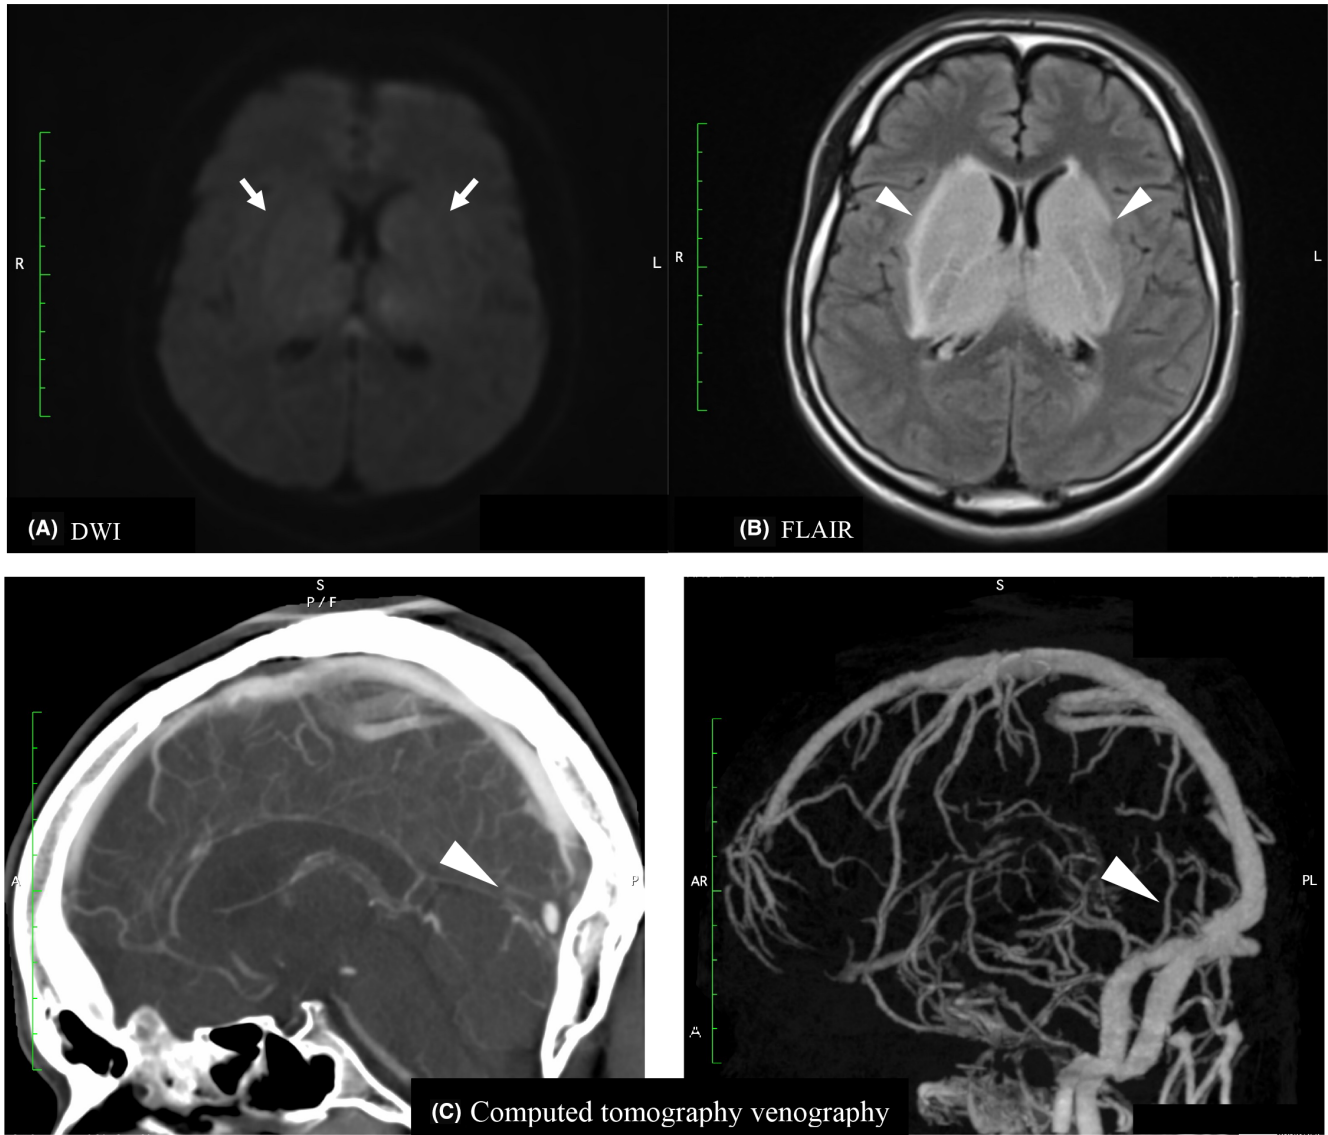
(A, B) Magnetic resonance imaging of a 20-year-old man with cerebral venous thrombosis. Reverse diffusion weighted image (DWI)–fluid attenuated inversion recovery (FLAIR) mismatch is identified, which shows the more precise high-intensity area in FLAIR (B, arrowheads) than in DWI (A, arrows), of the bilateral thalamic lesions. (C) Computed tomography venography showed the absence of contrast effect as the result of occlusion of the straight sinus (arrowheads).
